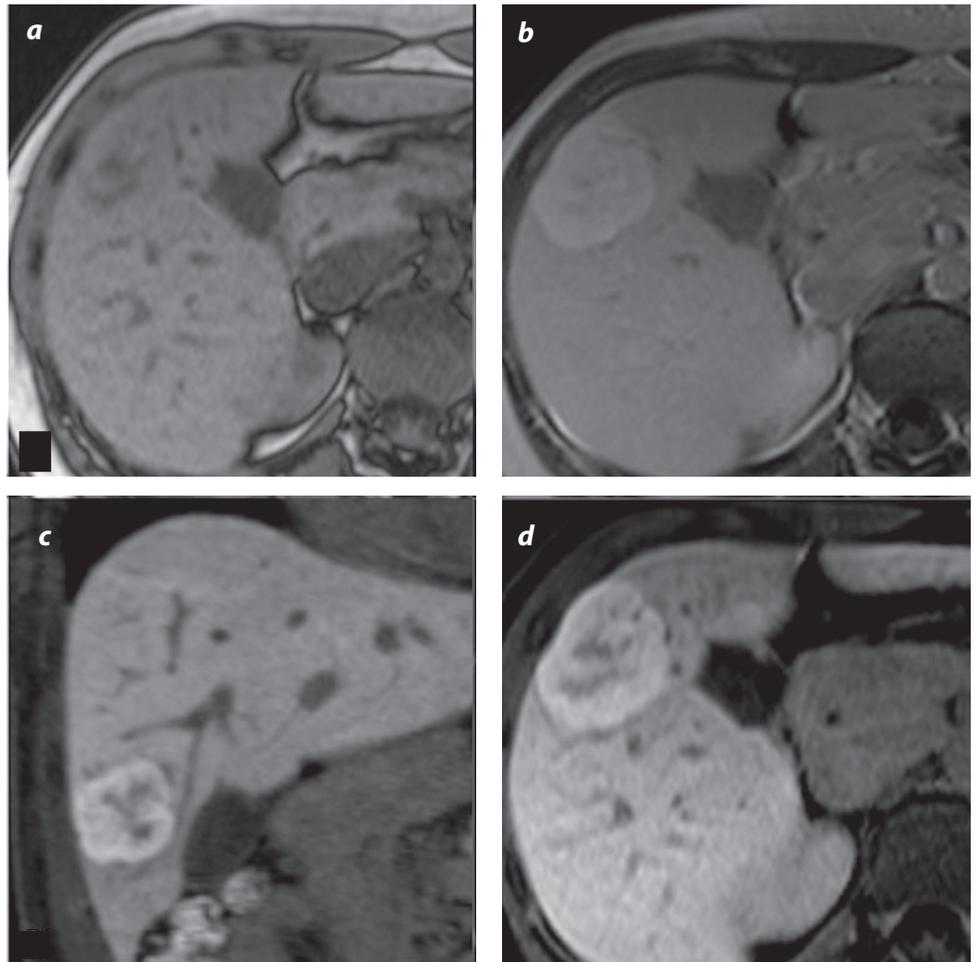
Magnetic resonance imaging. a) Sequence with out of phase T1 information in the axial plane. An isointense lesion is observed towards the hepatic parenchyma in segment V. b) Sequence with T1 information in post-contrast with disodium gadoxetate in the portal phase, a hypervascular lesion is shown. c) y d) Sequence with axial and coronal T1 information with fat saturation in the hepatobiliary phase. The retention of the contrast medium is observed through the lesion, demonstrating high signal intensity.
